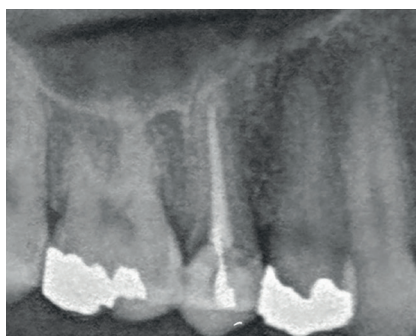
Pre-op radiograph.
